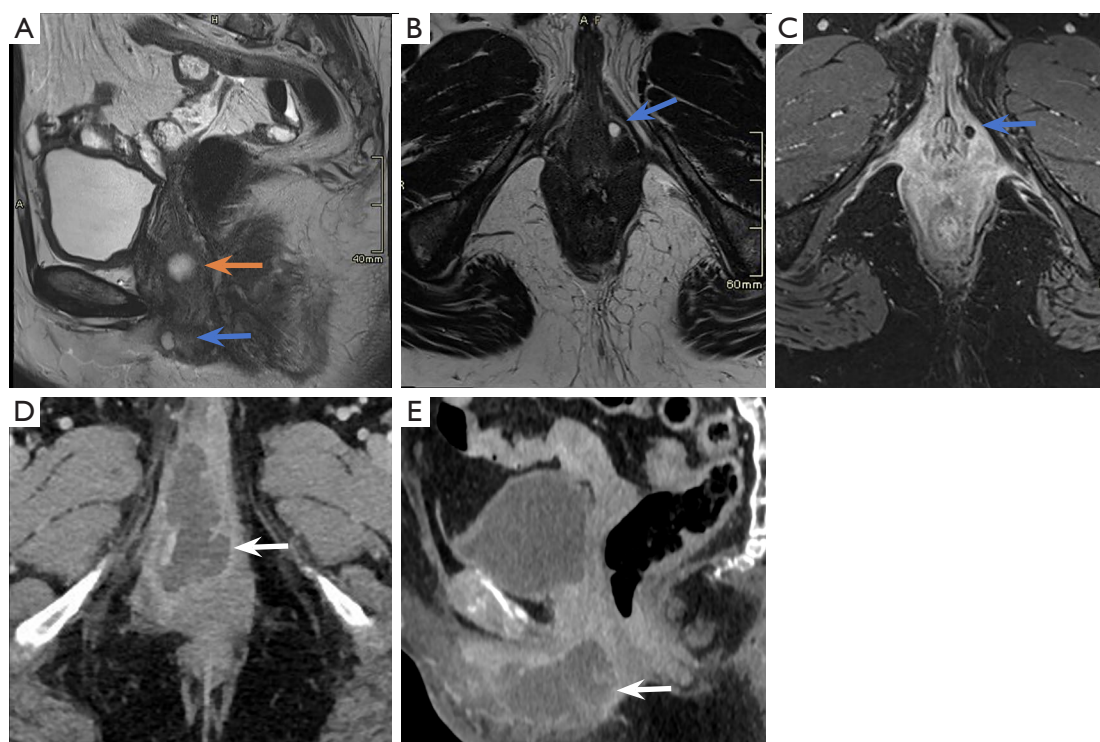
Bartholin's gland cyst with and without superinfection. (A-C) MRI: uncomplicated cyst (blue arrows), hyperintense on T2, located below the perineal membrane. No enhancement is seen on VSD (C). A urethral diverticulum is also visible (orange arrow). (D,E) CT: superinfected Bartholin's cyst with multilobulated wall, septations, and peripheral enhancement (white arrows). CT, computed tomography; MRI, magnetic resonance imaging; VSD, vaginal saline distension.
